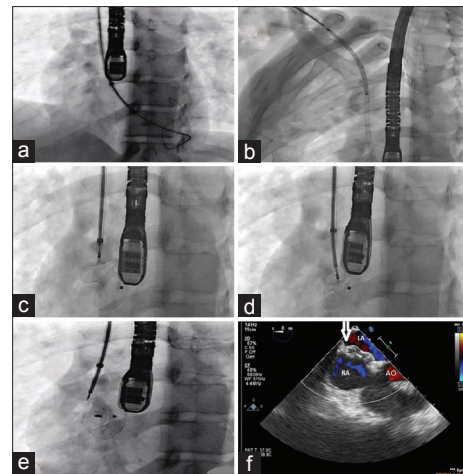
Transesophageal echocardiography and fluoroscopy-guided closure steps through internal jugular approach: (a) stiff wire in the left ventricle (b) atrial septal occluder device within the delivery system, tip of the delivery catheter is in the left ventricle (c and d) opening steps of the right atrial disc (e) released atrial septal occluder device (f) Cessation of the interatrial shunt (white arrow: atrial septal occluder device, RA: Right atrium, LA: Left atrium, AO: Aortic valve)
